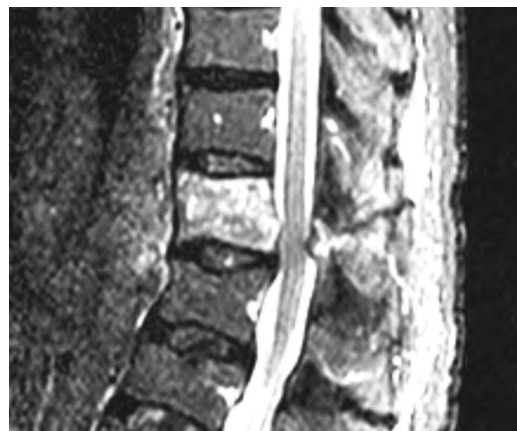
Magnetic resonance imaging scan showing a mild cord-compressing lesion with buckling of the ligamentum flavum.
